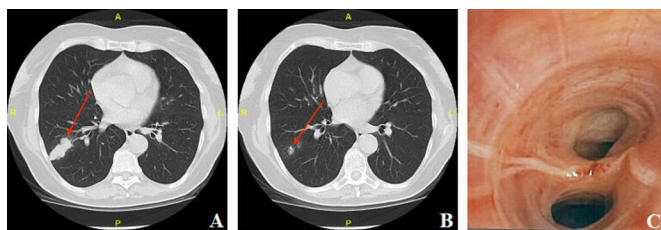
(A) Axial chest CT without contrast with arrow pointing to 4×1.8×2.1 cm mass in the lateral segment of the right lower lobe. (B) Axial chest CT without contrast, arrow pointing to a focus of calcification within the right lower lobe lung mass. (C) Bronchoscopy with evidence of small injury to a subcarina within the distal subsegments of the lateral segment of the right lower lobe.
